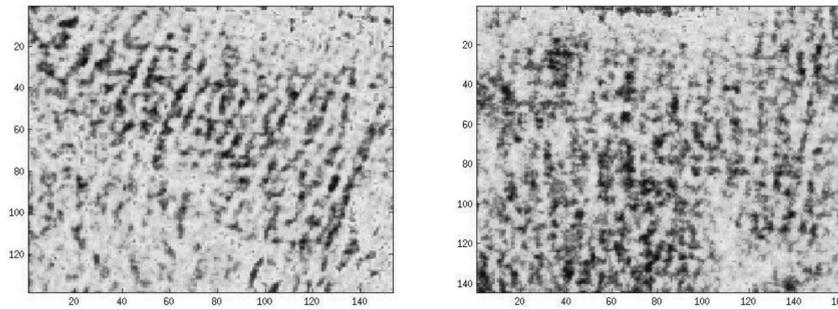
X-ray images of bone texture: normal (left) and OA (right).
